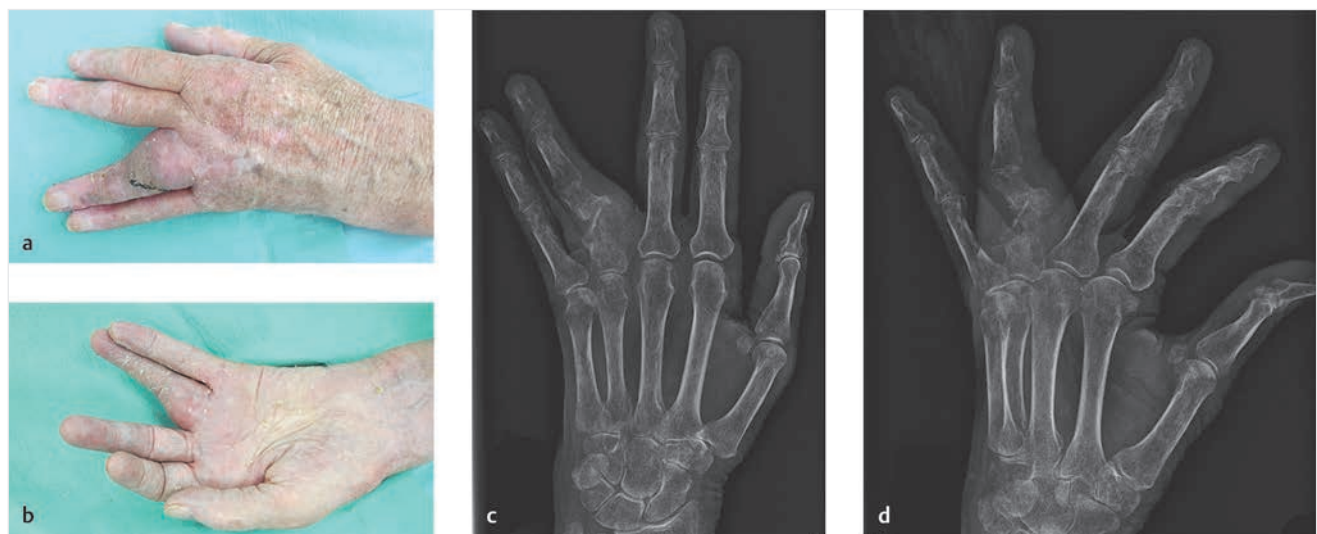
(a, b) Preoperative photos of the patient showing a large mass on the radial aspect of the proximal phalanx of the left ring finger. (c, d) Preoperative X-rays of the mass. (Continued)
